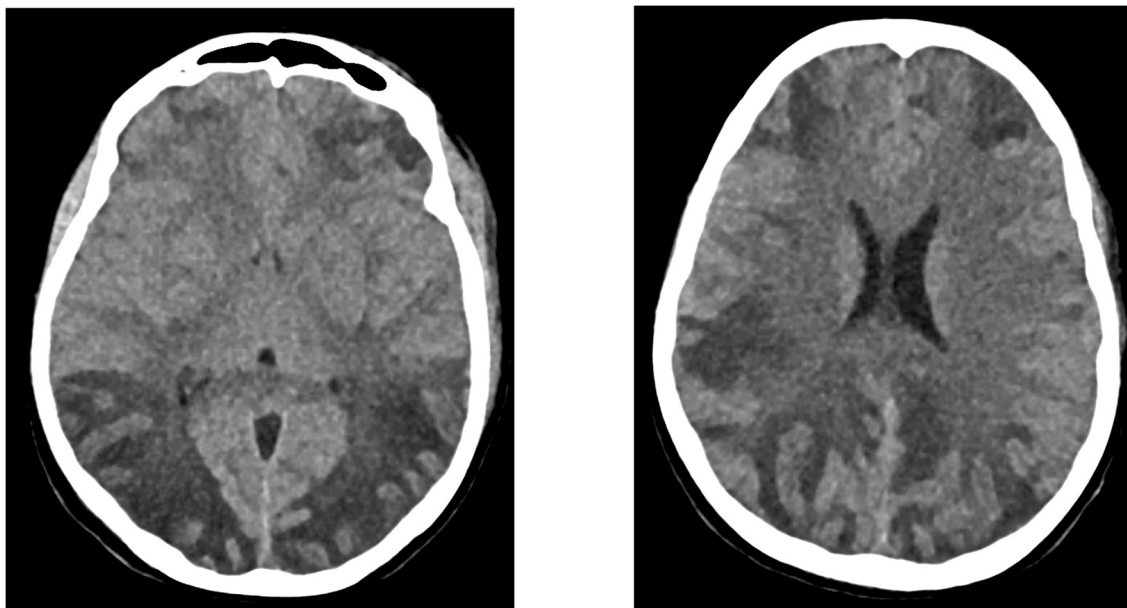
(A&B)-CT Brain: Axial plane shows Intra axial ill defined diffuse multi-focal hypo dense areas in the bilateral cerebral hemispheres predominantly in bilateral occipital lobes, Bilateral corona radiata, centrum semiovale, gangliocapsular region, with perifocal sub-cortical mild edema with effacement of adjacent sulcal spaces
